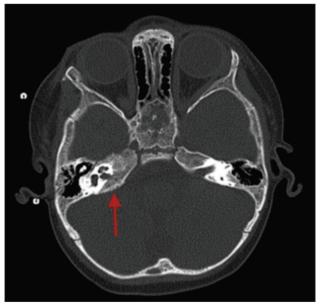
CT* scan of of a child who presented with a right LMN facial nerve palsy showing right petrous apex metastatic neuroblastoma (arrow).
